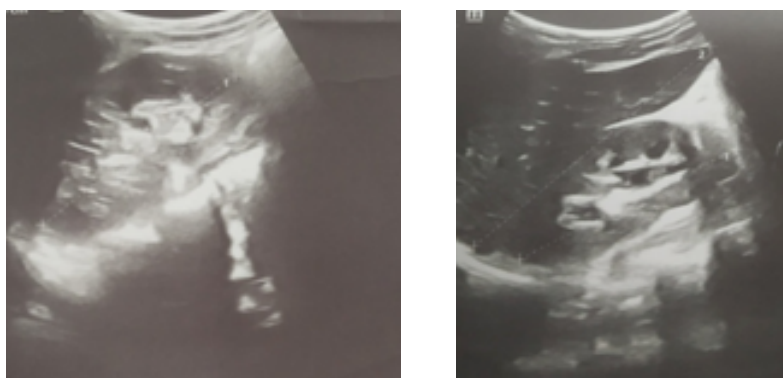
Ultrasound images of multiple angiomyolipomatous lesion of bilateral kidney
